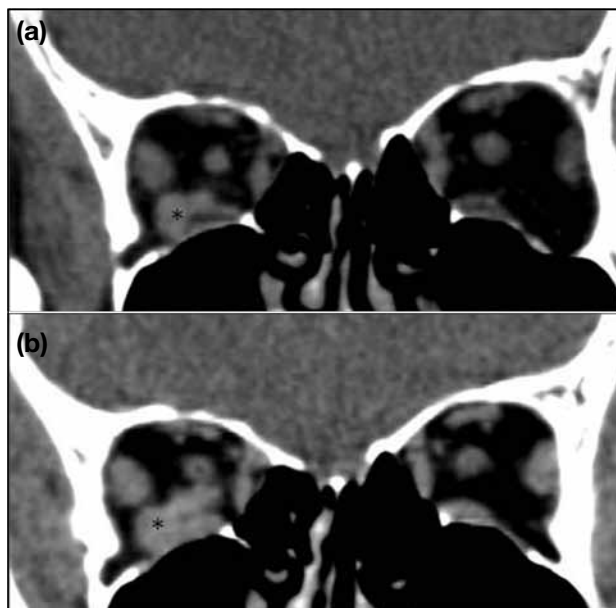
(a) Coronal-reformatted computed tomography of the orbit. Plain study at rest demonstrates the right retro-orbital lesion (asterisk) which is smaller in size 4 days following emergency lateral cantholysis of the right eye. (b) Contrast-enhanced study with Valsalva manoeuvre shows enlargement of the lesion (asterisk) with minimal enhancement.
